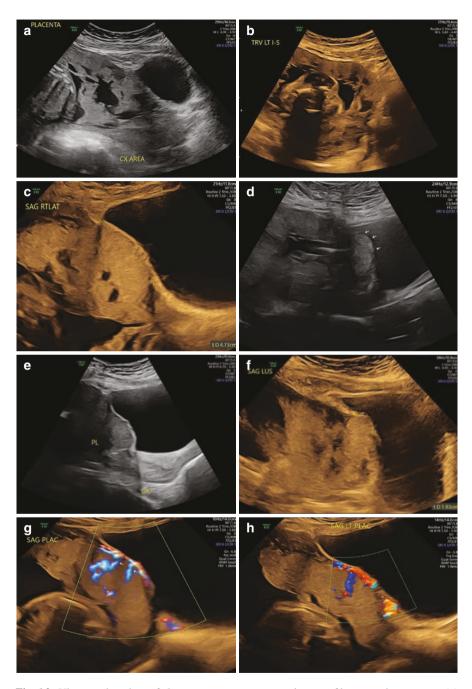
Ultrasound markers of placenta accreta spectrum on images of lower uterine segment; (a) sagittal view with placenta lacunae present; (b) transverse view with placenta lacunae present; (c) loss of the retroplacental hypoechoic zone between the placenta and myometrium; (d, e). sagittal view with irregular uteroplacental interface and bulging of the placenta toward the bladder with loss of the retroplacental hypoechoic zone between the placenta and myometrium; (f) sagittal view of placental extrusion beyond the uterine wall into the bladder; (g, h) sagittal view of hypervascularity of the placenta myometrium interface with bridging vessels
